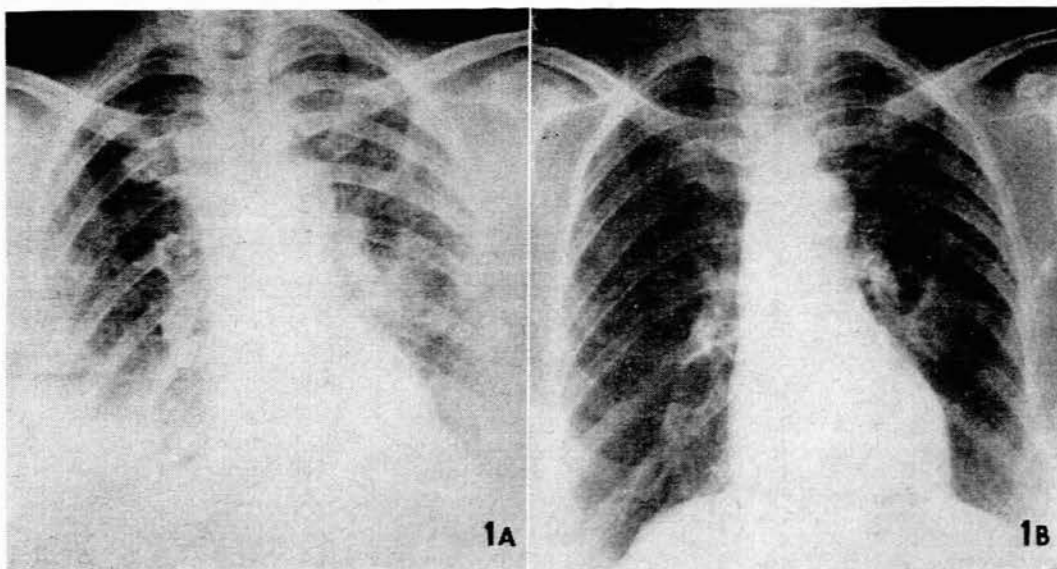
Patient with secondary lung deposits. A. Chest X-ray shortly before oophorectomy. B. Chest X-ray 4 months after oophorectomy. Note the vast improvement.
